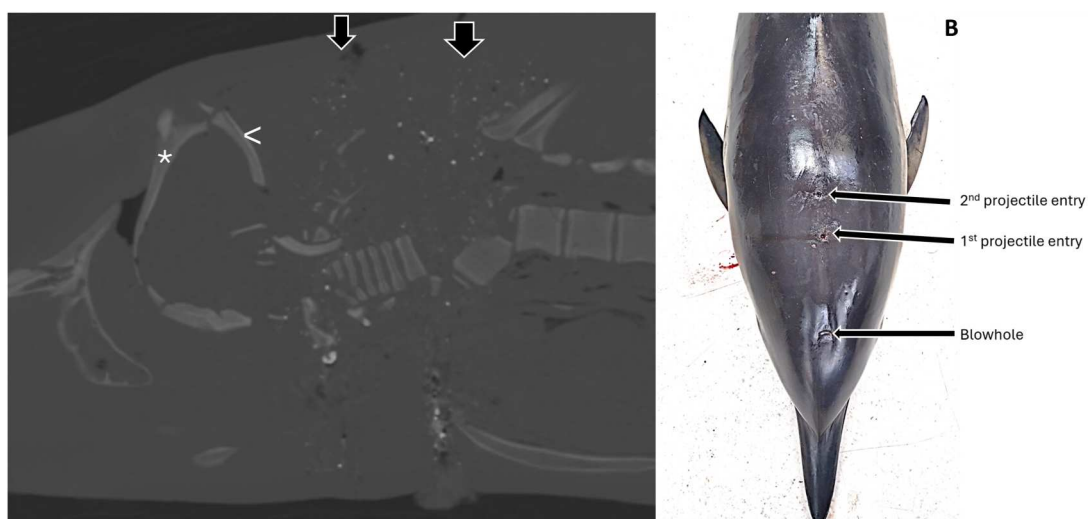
Images of a common dolphin (*Delphinus delphis*) that was shot twice from a dorso-ventral approach on the dorsal midline caudal to the blowhole. (A) Parasagittal multiplanar reconstruction CT in a high-frequency algorithm with an extended CT scale (window width: 9,000 HU; window level: 2,000 HU) showing the first entry wound at the level of the occipital-cervical junction (thin black arrow) and the second, more caudally at the level of the cervicothoracic junction (thick black arrow). Note the severity of the vertebral fractures and rostro-caudal compression of the calvarium to the left of the image. The frontal bone (*) and supraoccipital bone (>) are indicated. (B) External view showing two dorso-ventral projectile entry wounds on the dorsal midline caudal to the blowhole.
